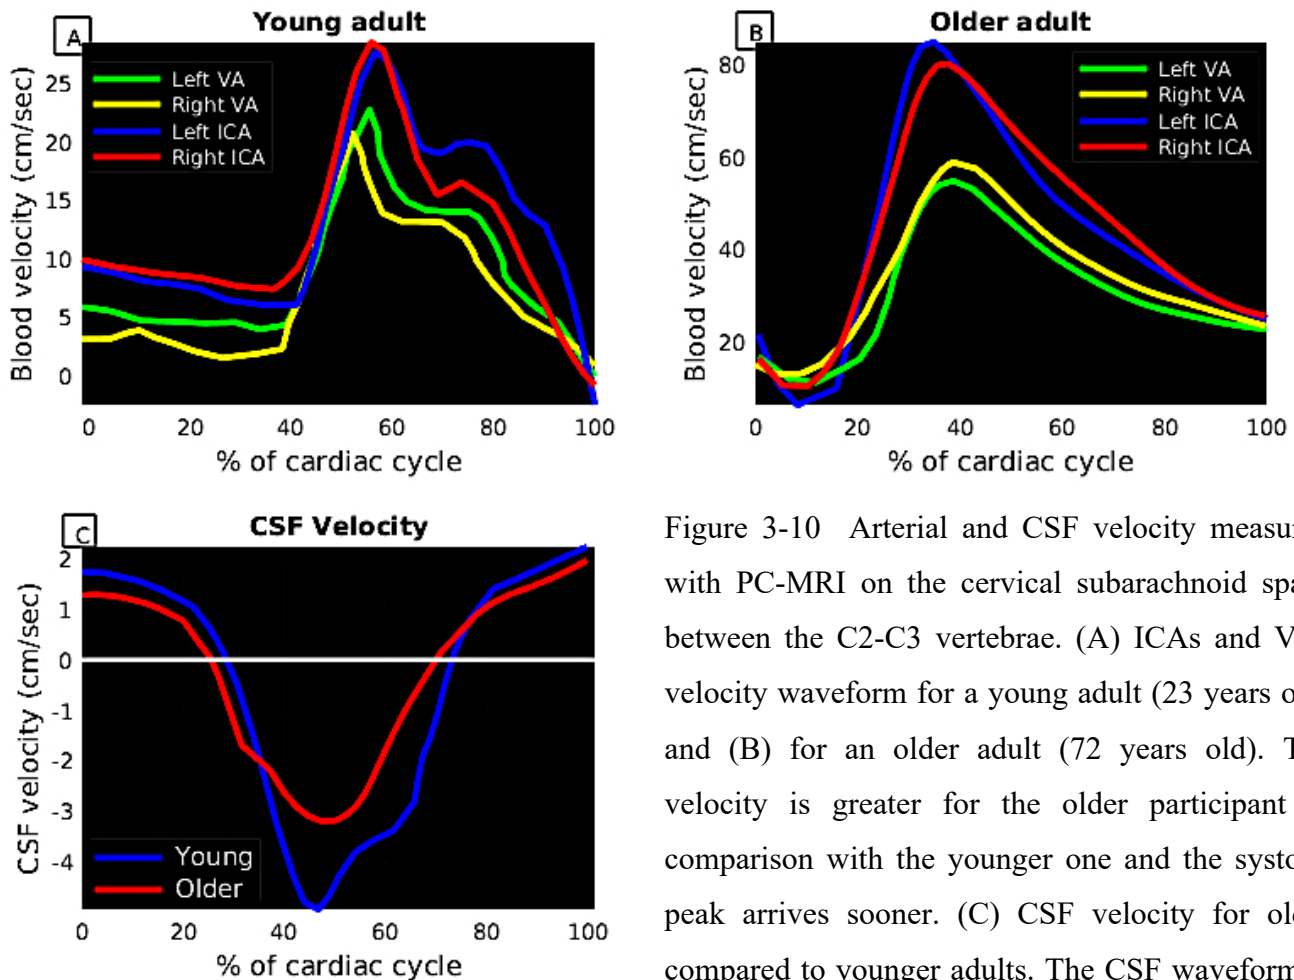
Arterial and CSF velocity measured with PC-MRI on the cervical subarachnoid space between the C2-C3 vertebrae. (A) ICAs and VAs velocity waveform for a young adult (23 years old) and (B) for an older adult (72 years old). The velocity is greater for the older participant in comparison with the younger one and the systolic peak arrives sooner. (C) CSF velocity for older compared to younger adults. The CSF waveform is sharper for young adults than for young adults.
